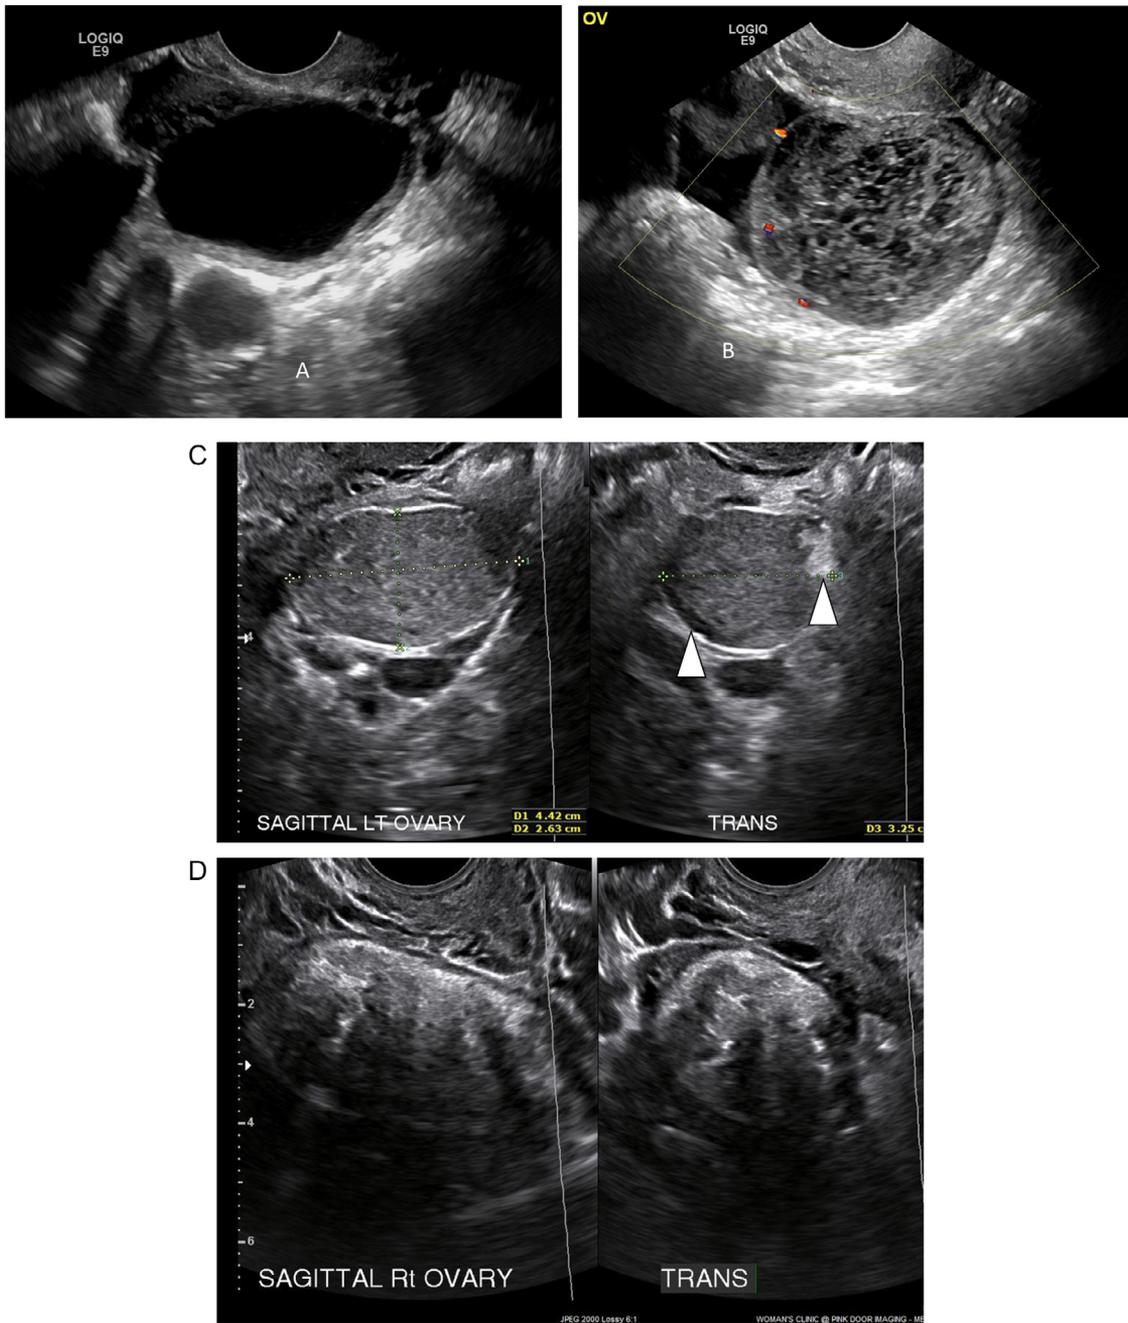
GI-RADS 2 very probably benign. (A) Simple unilocular cyst that resolved at follow-up (not shown). (B) A unilocular cyst with lace like internal echoes consistent with a hemorrhagic cyst. (C) GI-RADS 2. Very probably benign. Unilocular cyst with compact internal echoes with hyperechoic component (arrowhead) and a peripheral curvilinear lucency (arrowhead) suggestive of an endometrioma. (D) GI-RADS 3. Probably benign. A solid ovarian tumor with hyperechogenicities and posterior acoustic shadowing. (E) GI-RADS 5. Very probably malignant. Ultrasound shows a large predominantly solid mass with ascites. (F) GI-RADS 4. Probably malignant. Real time and color Doppler images demonstrate a unilocular cyst with a large solid component demonstrating moderate vascularity within the solid component.
